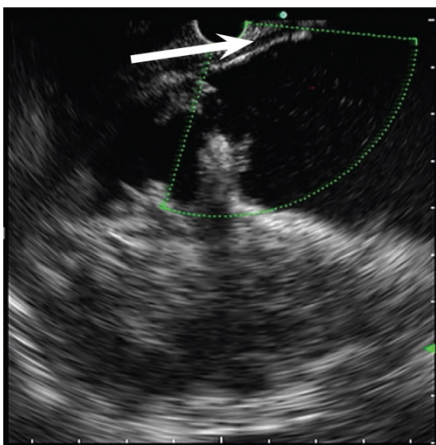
Endoultrasoundography (revealing avascular area)
